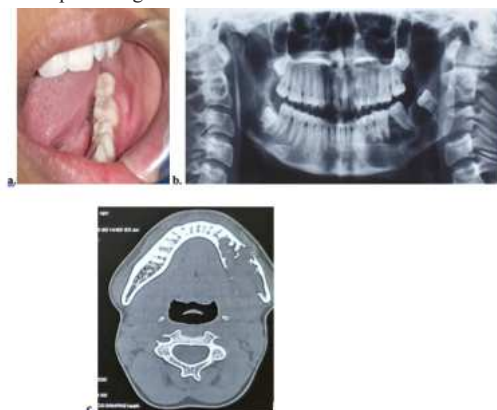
Pre operative photographs: (a) Clinical Intra oral photograph; (b) Preoperative Orthopantomogram revealing the extent of the lesion; (c) Preoperative Computed Tomography showing buccal and lingual cortical erosion.
